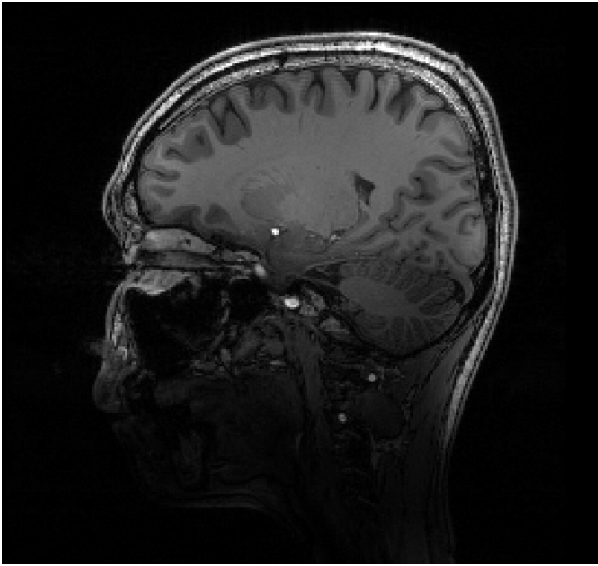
Sagittal slice of T1-weighted image with high inhomogeneity effect. The intensity of the image is lower in the inferior part of the image.
